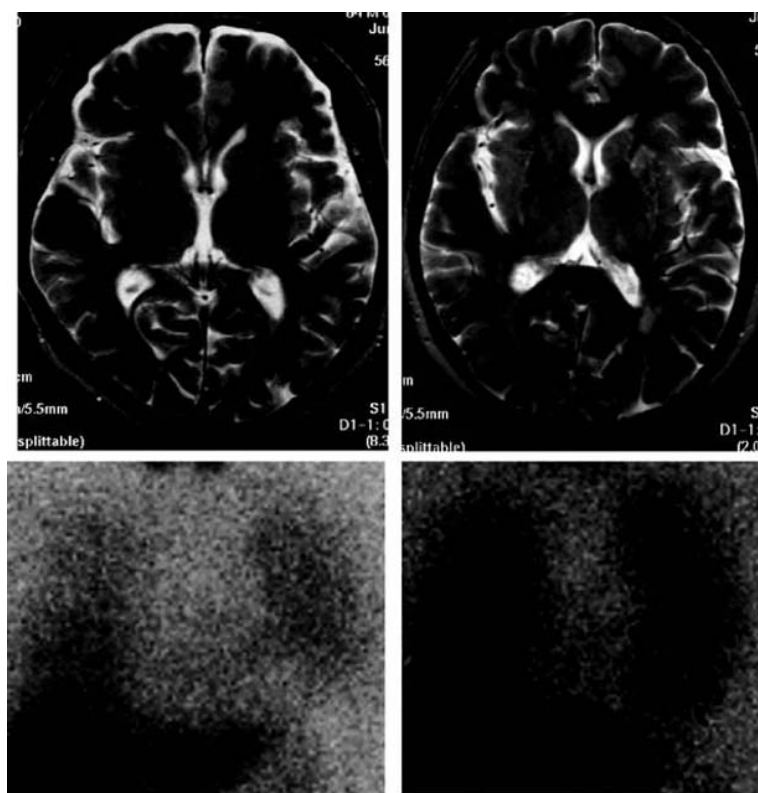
Left: 64-year-old man with PD. MRI is normal and cardiac MIBG uptake is markedly decreased. Right: 61-year-old woman with MSAp. The left putamen shows patchy T2-high signal lesions and the right putamen shows atrophic change, a T2-high signal lesion along the rim of the outer putamen and T2-low signal change within putamen. Cardiac MIBG uptake is normal. In this patient, the left side of the body showed more prominent symptoms.
